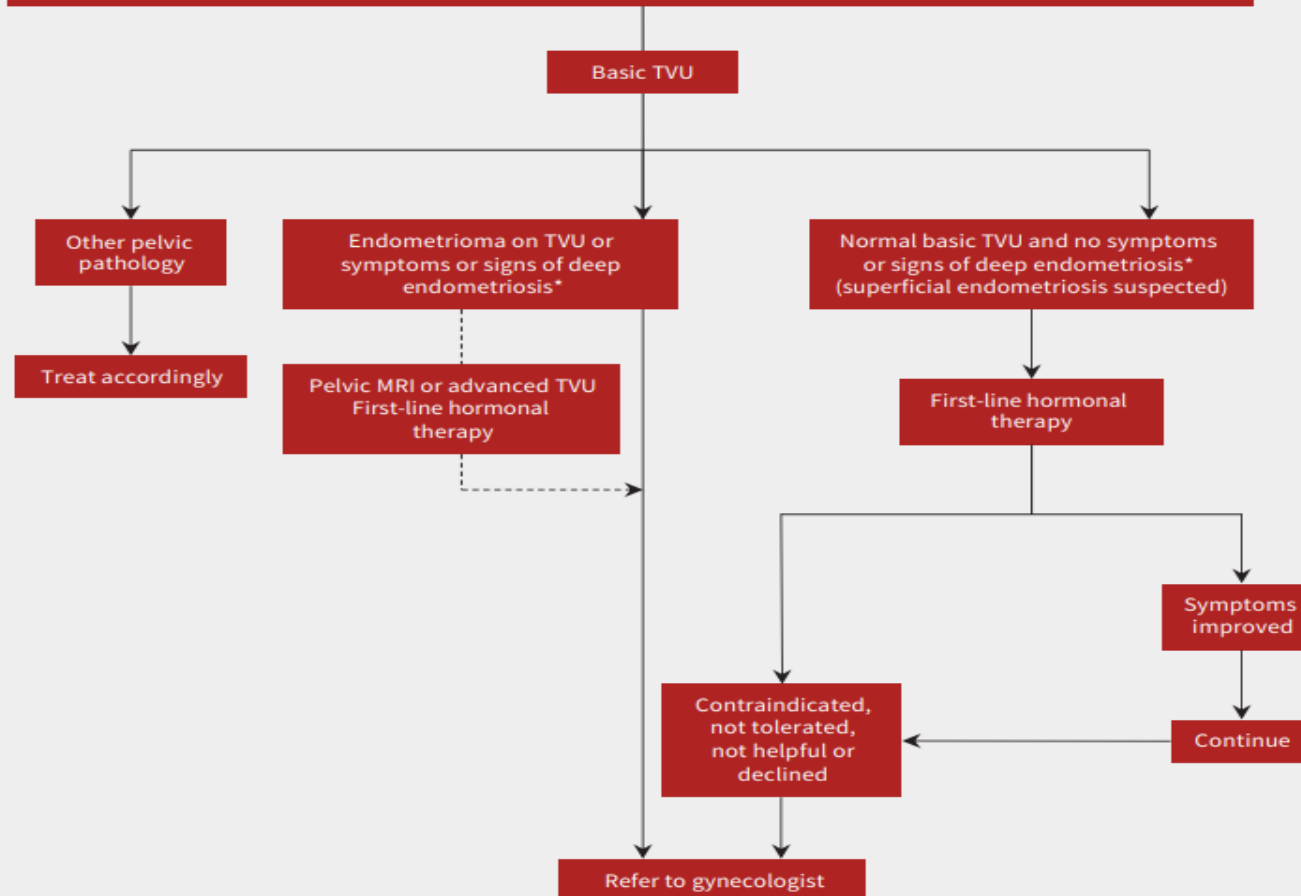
Diagnosis and first-line management of endometriosis. Note: BMI = body mass index, MRI = magnetic resonance imaging, SOB = shortness of breath, TVU = transvaginal ultrasonography. *Suspect deep endometriosis.
